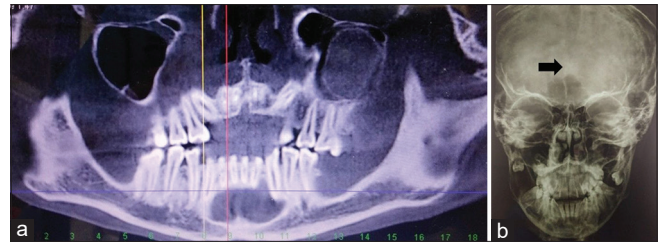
(a) Pre-operative Orthopantomogram of Case 2 revealing multiple radiolucencies involving mandibular anterior, and maxillary posterior region. (b) PA skull view of Case 2 showing calcification of falx cerebri. (PA: Posteroanterior)
